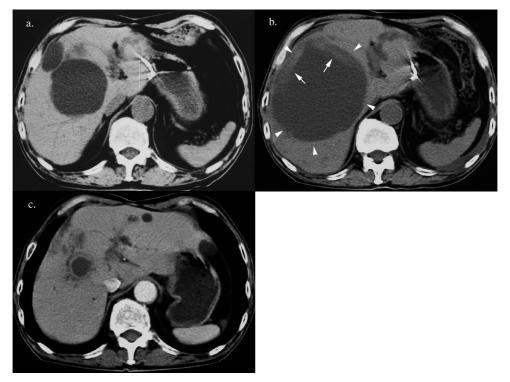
Computed tomograms (b) show remarkable enlargement of the liver cyst as compared with previously (a). The computed tomogram demonstrates a high density structure (arrow) in the cyst (arrowhead) and ascites including a high density area. There is no elevated lesion detected inside of the cystic wall, which indicates intracystic hemorrhage and spontaneous rupture of the liver cyst. (c) Computed tomogram four months after discharge from the hospital reveals that the cyst has decreased in size.
